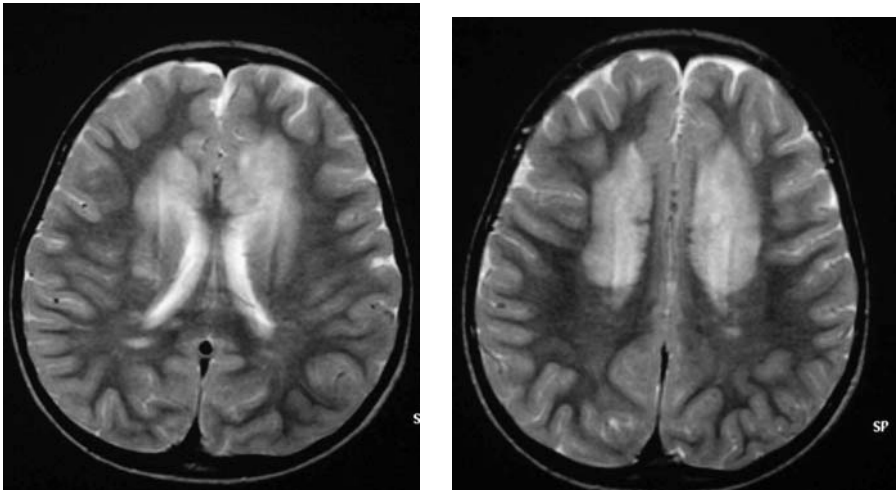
Appearance of T2-weighted images of the brain show increased signal intensity bilaterally and symmetrically in the periventricular and deep white matter (on the left) and the corona radiata (on the right). T1-weighted images were not remarkable. There was no enhancement after administration of gadolinium. Images are courtesy of Eric Faerber, M.D., Department of Radiology, St. Christopher's Hospital for Children, Philadelphia, USA
